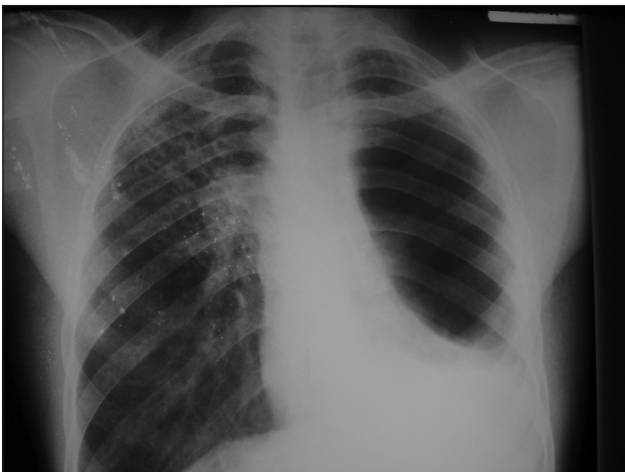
PA chest radiograph of HIV/PTB on HAART patient showing streaky opacities in the right upper zone. The right hilum is full with lobulated outline representing adenopathy. There is a homogenous opacity in the left lower zone obliterating both diaphragmatic and cardiac outline with tracking along the lateral chest wall. These appearances are in keeping with right upper zone fibrosis with right hilar adenopathy and left pleural fluid collection
